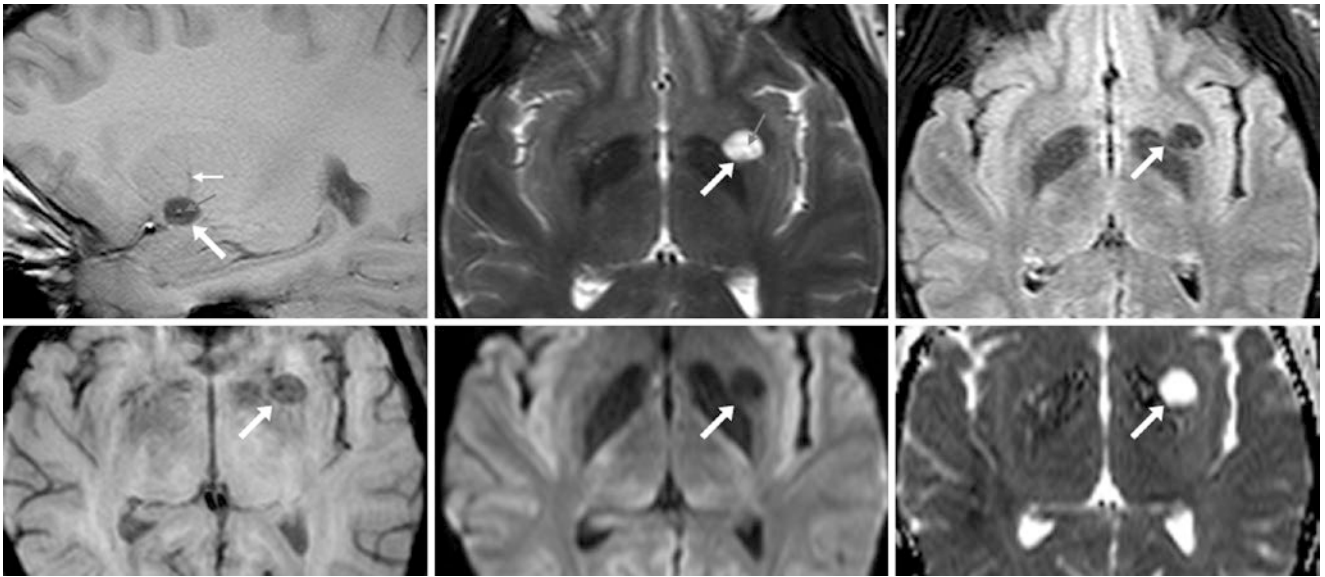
A 35 year old with a dilated PVS (arrows) on a sagittal T1WI (top left), axial T2WI (top middle), FLAIR (top right), SWI (bottom left), DWI (bottom middle), and an ADC map (bottom right). The
